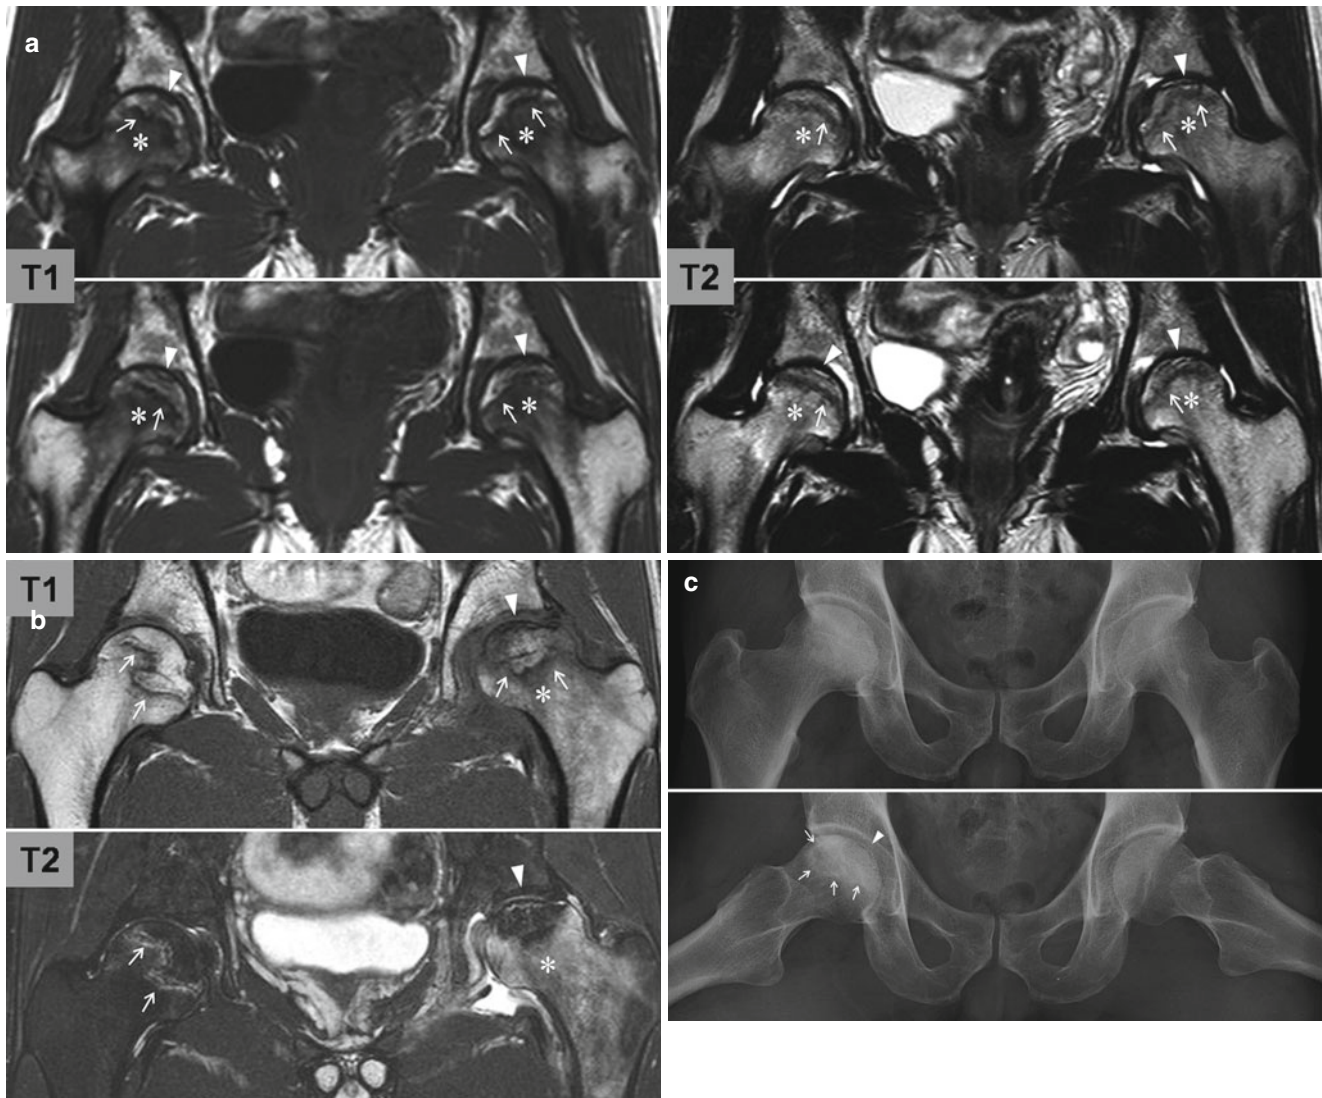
Image findings of osteonecrosis of the femoral head. (a) A 31-year-old woman had both left and right hip pain for 1 month. In addition to a subchondral fracture line (*arrow heads*), an outer abnormal signal band (reactive interface, *arrows*) is detected on MR images. The bone marrow edema pattern (*asterisks*) is located distal to the reactive interface. (b) A 28-year-old man had left hip pain for 6 months. There has been no pain in the right hip. In the left hip, a subchondral fracture line (*arrow heads*) is observed proximal to the reactive interface
